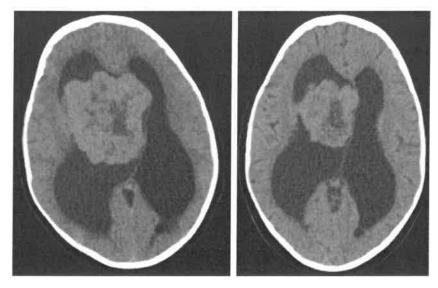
Patients' tumor at baseline on left and post 20 days of everolimus on right. (67% reduction of tumor size). Non-contrast CT.
